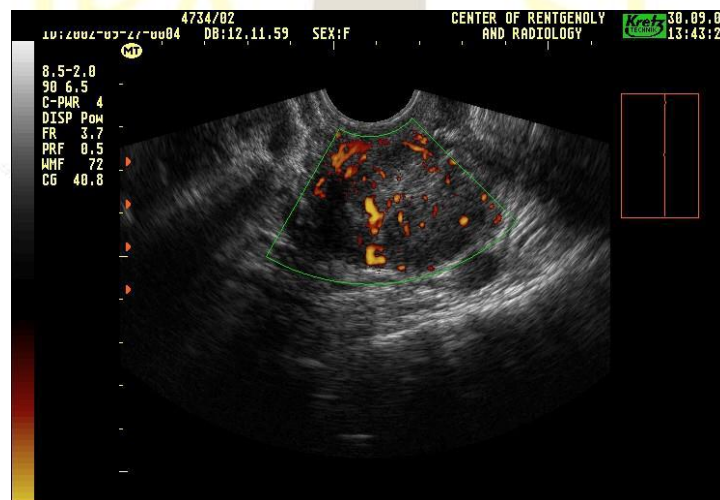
Doppler SEM stage IIA in the EDC mode.
